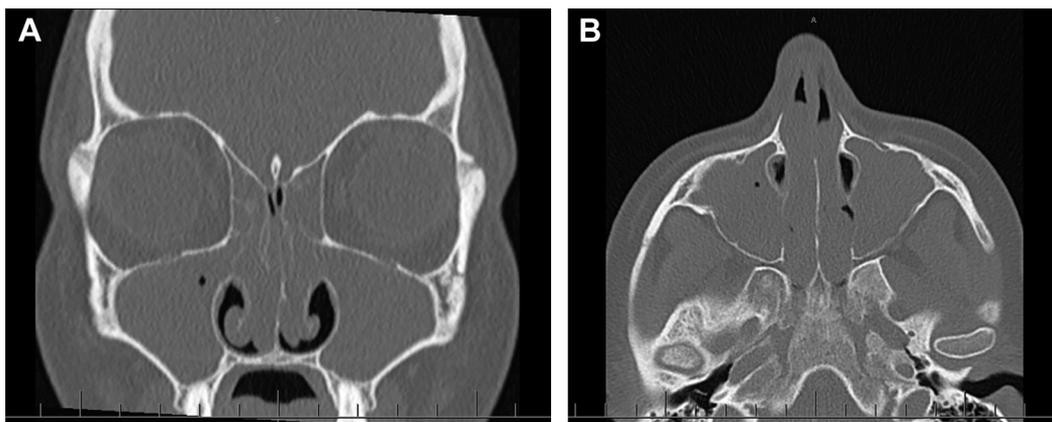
A and B, Computed tomography scan of sinuses showing nasal polyposis and pansinusitis.
